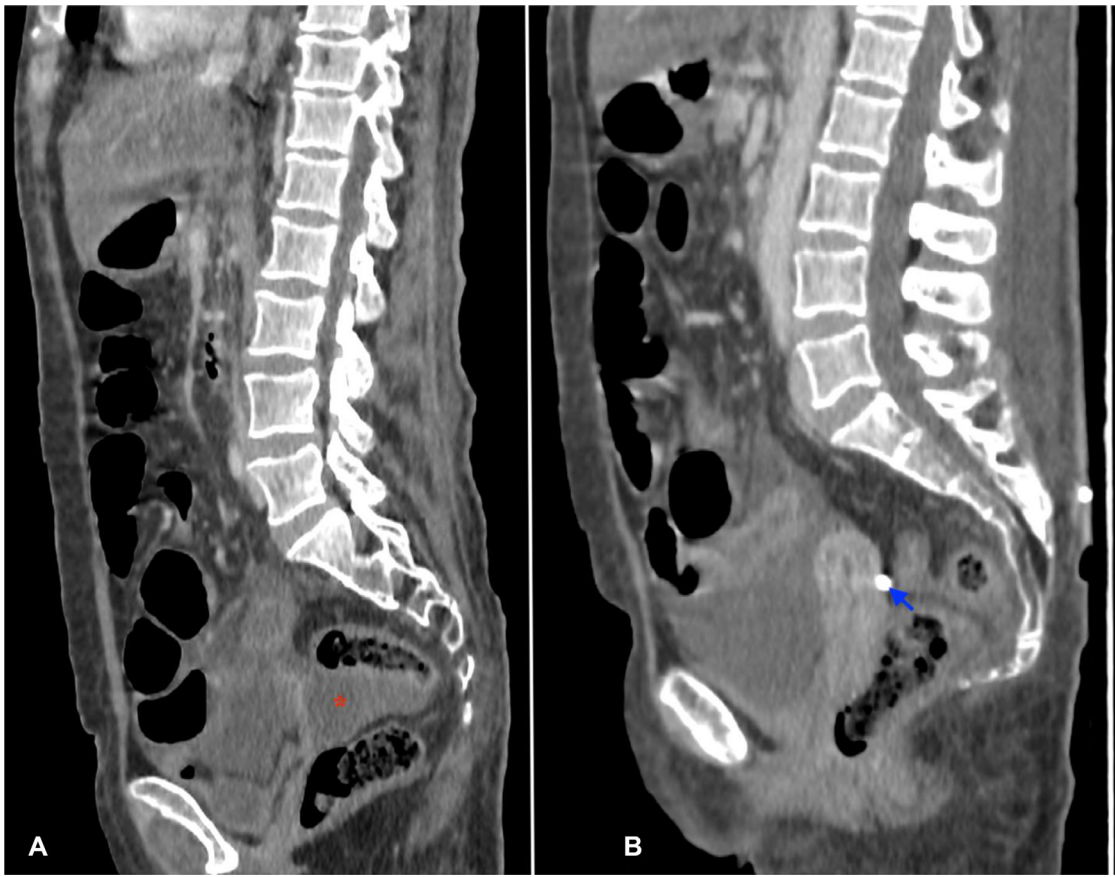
Sagittal CT-SCAN of our 52-year-old female patient pelvis after intravenous contrast administration before and J-1 after drainage showing peritoneal fluid within the Douglas pouch (red asterisk in A) and the catheter tip (blue arrow).
